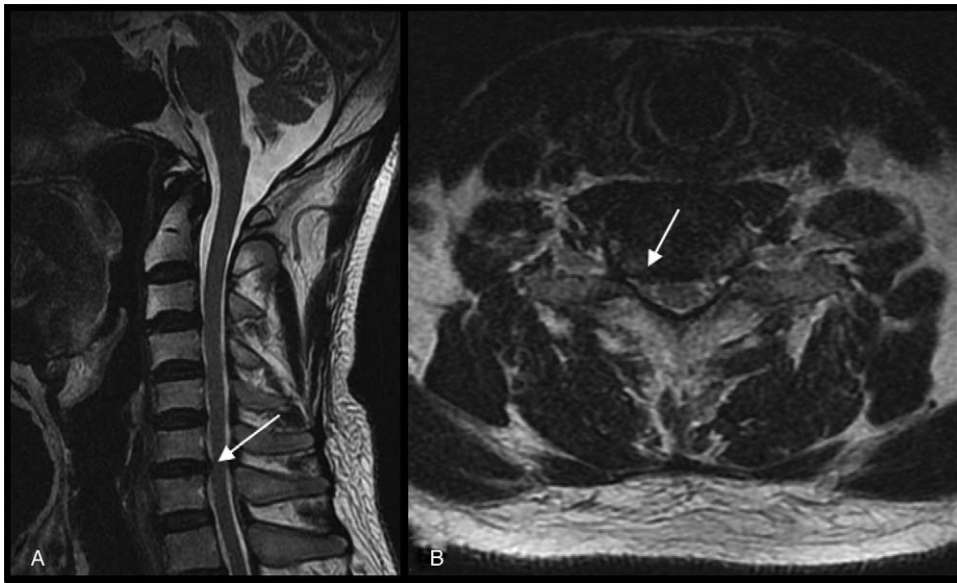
Magnetic resonance image of cervical spine revealing a mild right central herniated disc at the C6/7 level in the sagittal (A) or axial (B) view.
